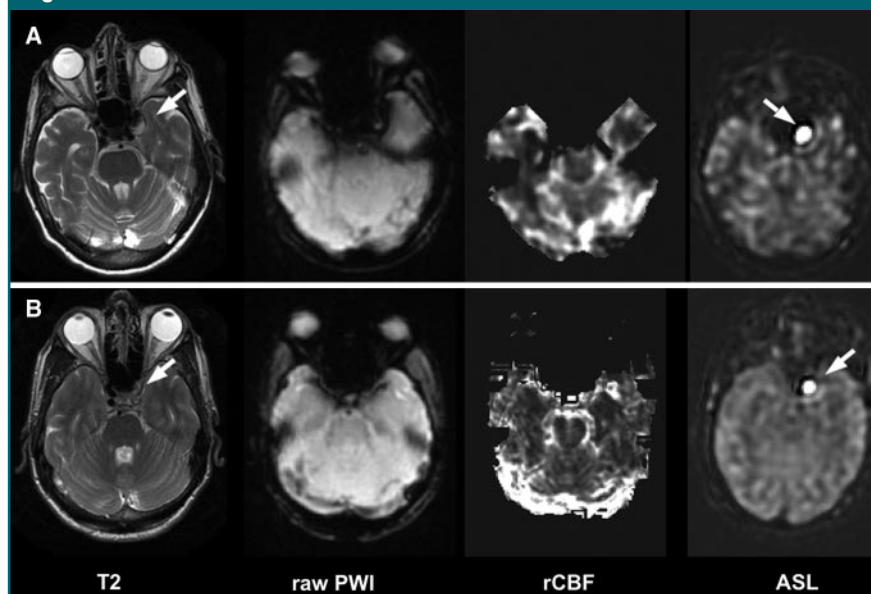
High ASL signal in setting of stagnant or slow blood flow in vascular structures. T2-weighted fast spin-echo (T2) (4717/85), raw gradient-echo echo-planar PW (PWI) (1225/17), and ASL MR images, and relative CBF (rCBF) maps (1225/17, 30, 52) are shown for comparative purposes. *A*, Imaging findings in 84-year-old woman with a 15-mm left cavernous carotid aneurysm (arrows). *B*, Imaging findings in 58-year-old man with chronic left internal carotid artery occlusion (arrow on T2-weighted image) at carotid bifurcation. On ASL image, the high signal (arrow) in ipsilateral cavernous carotid artery possibly represents slow or stagnant retrograde blood flow via the anterior communicating and/or ophthalmic arteries.
